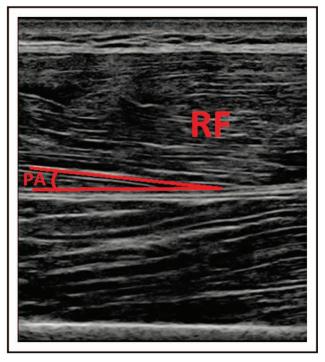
Visualization of the pennation angle (the angle between muscle fascicles and the tendon axis) on a long-axis ultrasound image of the rectus femoris muscle. PA, pennation angle.
